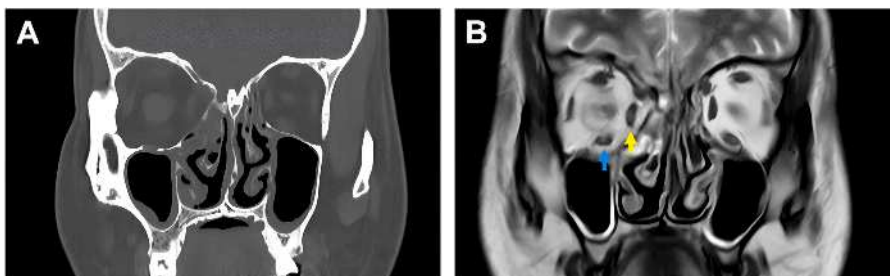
(A) High resolution coronal CT image demonstrating a right-sided fracture of the orbital floor and medial wall. (B) Coronal MRI image of the same patient, revealing high definition of soft tissues, good visualization of orbital volume expansion. The image shows change in orientation of inferior rectus (blue arrow) and medial rectus (yellow arrow) and herniation of intraorbital fat into the maxillary and ethmoid sinuses.
